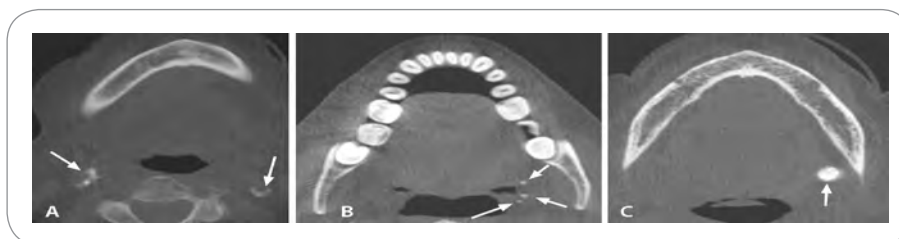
Calcifications in the soft tissues in the neck area. Data acquired using an iCAT CBCT machine. Images were reformatted in iCATVision software. (A) Axial section shows bilateral calcified carotid atheromas with irregularly curved margins. (B) Axial section shows discrete tonsillar calcifications. (C) Axial section shows a well-defined sialolith in the submandibular gland.
